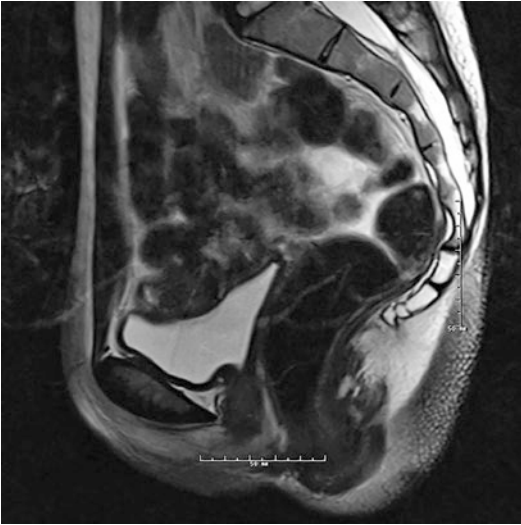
Magnetic resonance image of Müllerian agenesis. Typical findings in the pelvis include normal ovaries and fallopian tubes and usually small Müllerian remnants attached to the proximal portion of the fallopian tubes that may be solid or have functioning endometrial tissue
